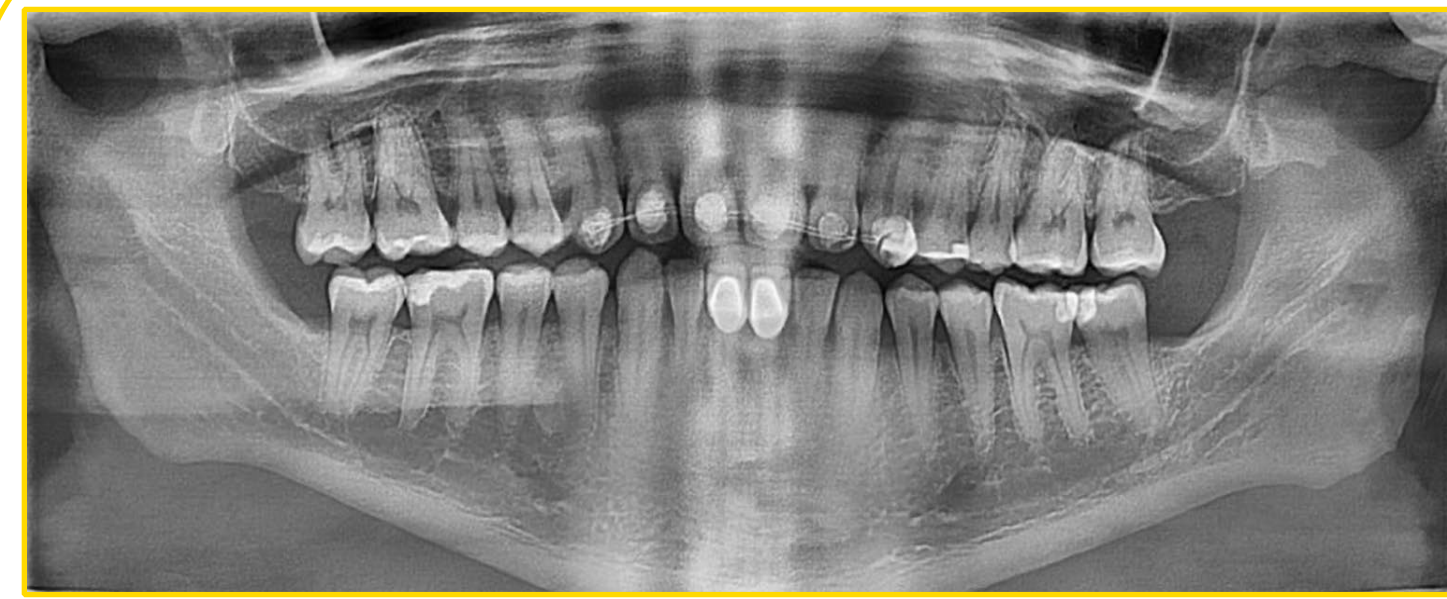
Panoramic radiograph taken on the time of tooth reimplantation
